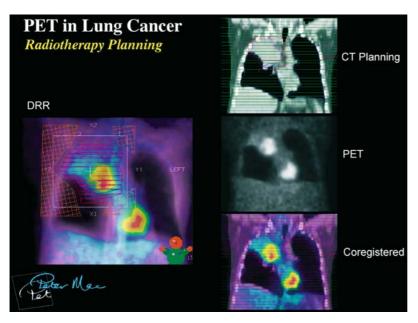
PET in radiotherapy planning. These images are all from a single patient with NSCLC planned for radical radiotherapy. *left* PET scan superimposed on digitally reconstructed radiograph, *right upper* planning CT scan with target volume marked, *right middle* PET scan, *right lower* coregistered PET and planning CT scans
